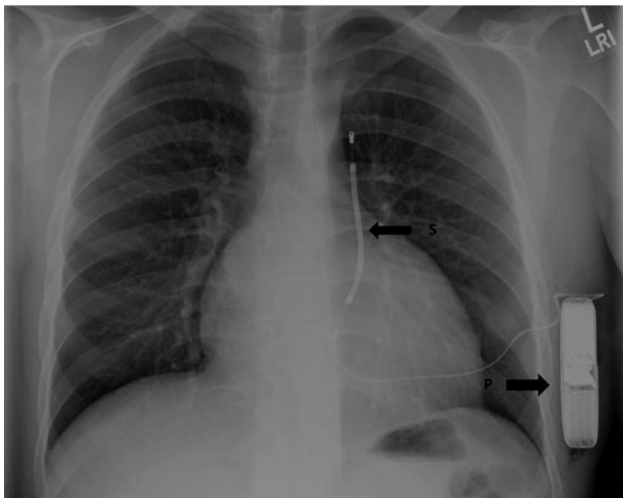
Chest radiograph demonstrating a subcutaneous pacemaker system. P, pulse generator; S, subcutaneous lead with shock coil.
